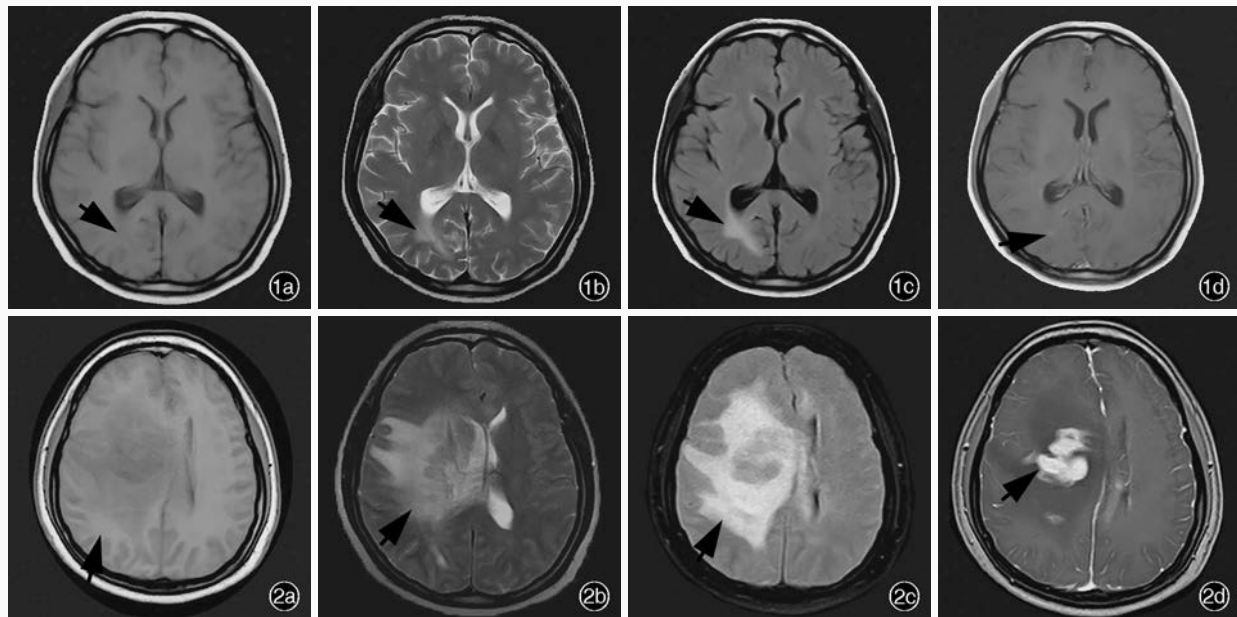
2012 年头部 MRI 检查所见 1a 横断面 T₁WI 显示, 右侧顶枕叶略低信号影(箭头所示) 1b 横断面 T₂WI 显示, 右侧顶枕叶高信号影(箭头所示) 1c 横断面 FLAIR 成像显示, 右侧顶枕叶高信号影(箭头所示) 1d 横断面增强 T₁WI 显示, 右侧顶枕叶病灶呈点状强化(箭头所示) 图 2 2013 年头部 MRI 检查所见 2a 横断面 T₁WI 显示, 右侧额顶叶低信号影, 约 6 cm × 5 cm × 3 cm (箭头所示) 2b 横断面 T₂WI 显示, 右侧额顶叶高信号影(箭头所示) 2c 横断面 FLAIR 成像显示, 右侧额顶叶高信号影(箭头所示) 2d 横断面增强 T₁WI 显示, 右侧额顶叶病灶呈均匀强化, 周围脑组织水肿(箭头所示)
